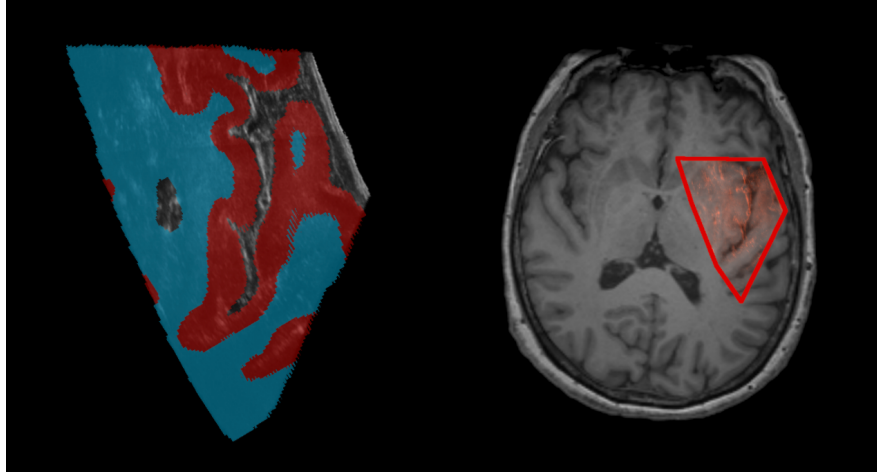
Stimulus material presented to the participants during the US segmentation rating experiment. One trial consisted of the presentation of a US image (left) with the source area delineated in a corresponding MR image (right). In addition, the star rating assessment control elements were displayed analog to the BraTS experiment, see Figure 2. As in the previous experiment, participants could toggle the display of segmentation maps for grey- and white matter with the space bar. Further details regarding the stimulus presentation are outlined in Section Section 2.1
